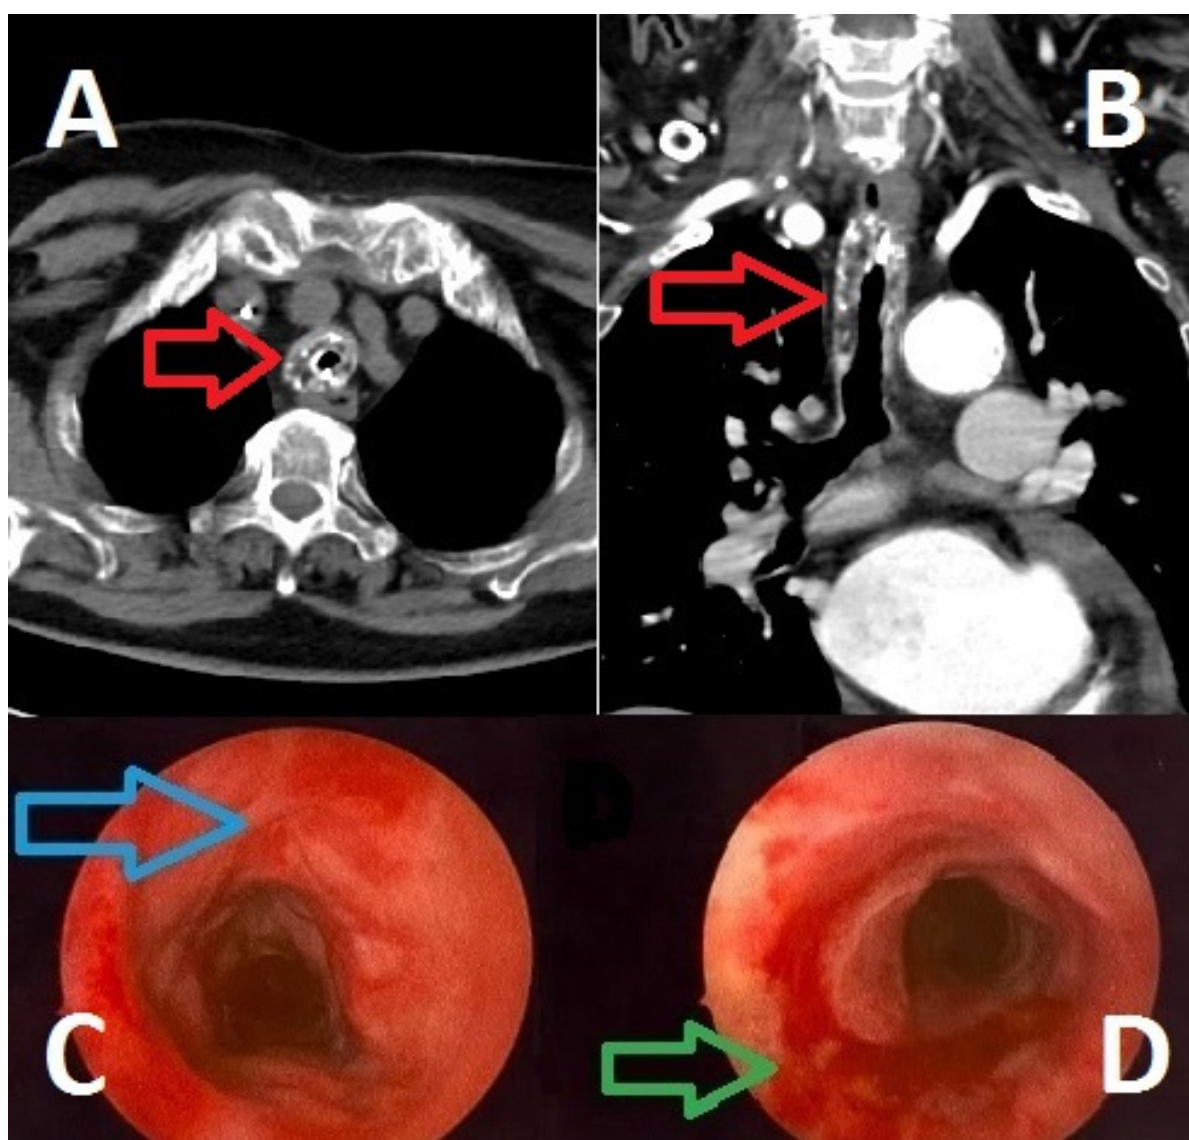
CT and endoscopic images
